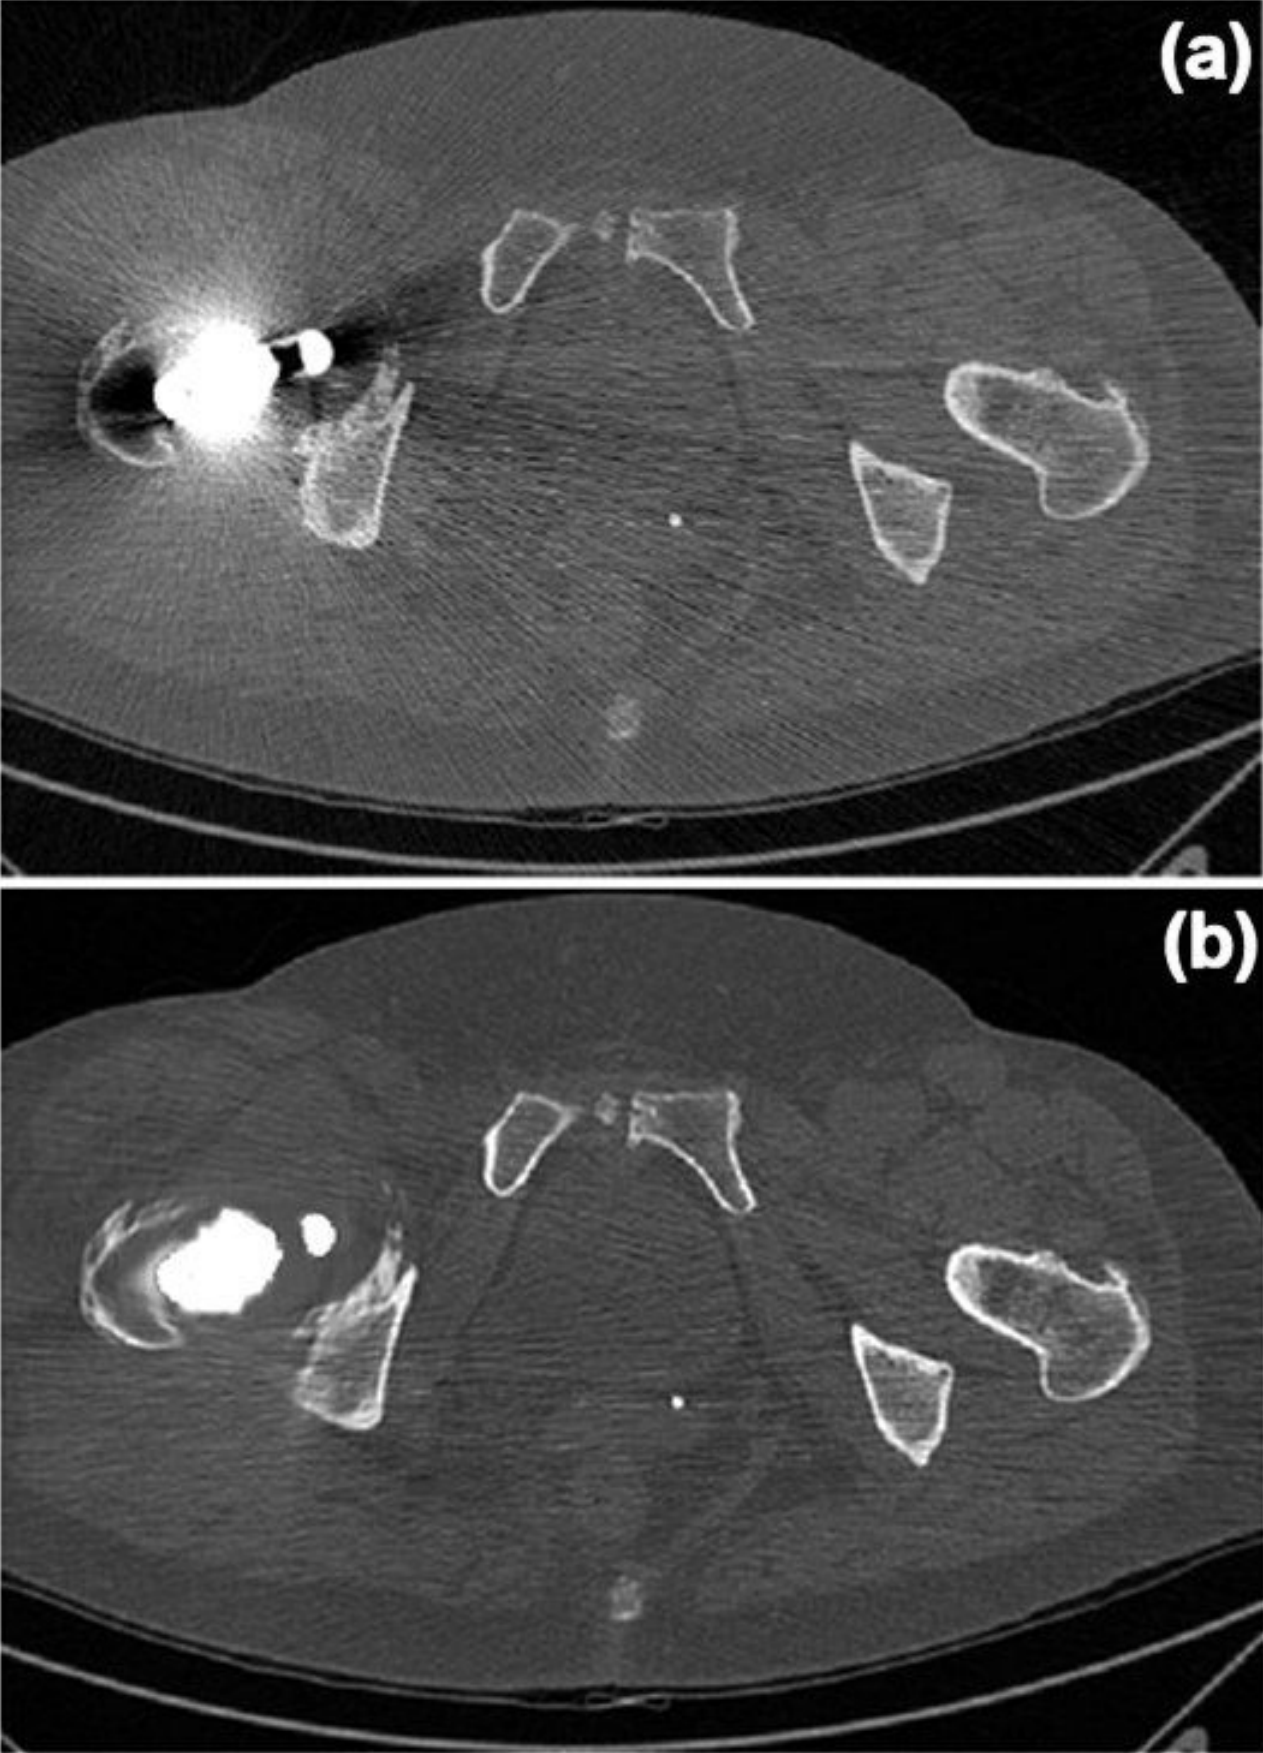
(a) a raw CT slice enclosing the metal prosthesis ; (b) the same slice after Metal Artifact Reduction
